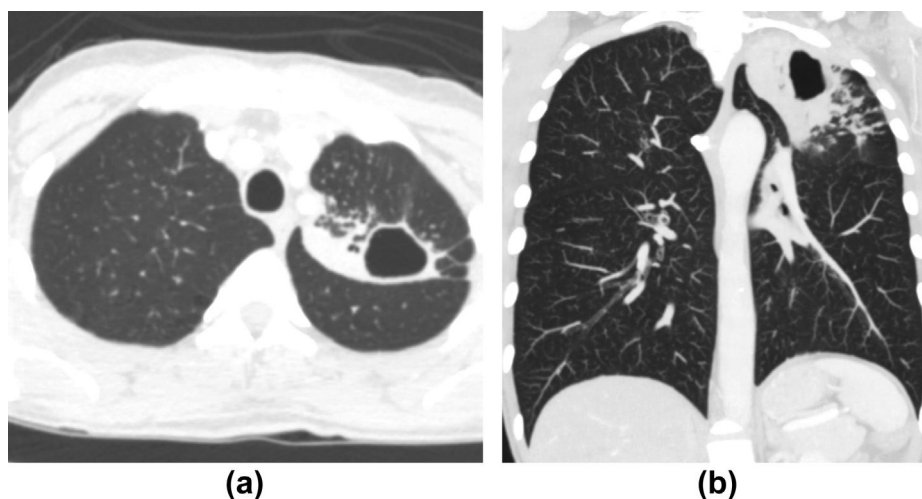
A 50-year-old man with active tuberculosis. (a) Axial CT image demonstrates a thin-walled cavitory lesion in the left upper lobe of the lung. (b) Coronal CT reformatted image evidences perilesional centrilobular nodules. The culture from bronchoalveolar lavage was positive for *M. tuberculosis*.
